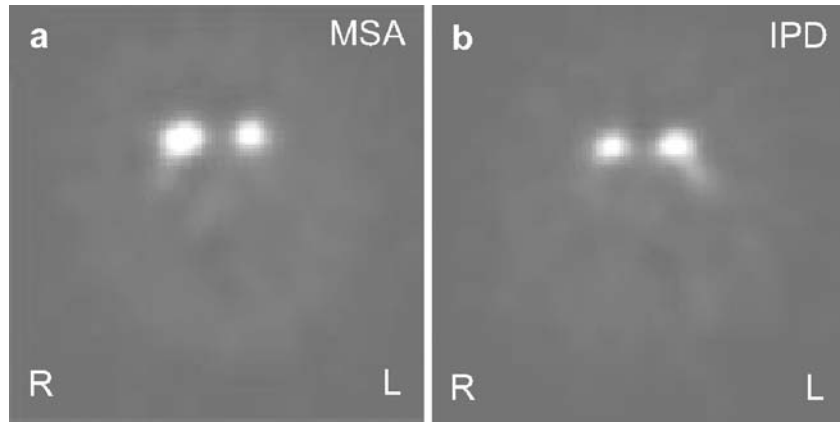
Baseline [^{123}I] β -CIT SPECT images of two patients with a parkinsonian syndrome. Transverse slices from the brain at the level of the striatum (approximately 3 cm above the orbitomeatal line). Levels of SPECT activity are coded from low (black) to high (white) and have been scaled to the maximum pixel value in each individual image. a Patient suffering from MSA, with relatively spared caudate
